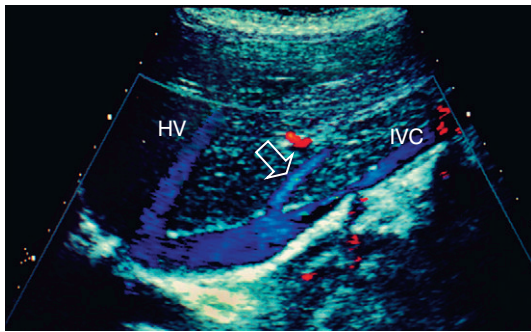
Longitudinal colour Doppler image of the liver and inferior vena cava (IVC) through the right flank. There is a prominent accessory hepatic vein (open arrow) from the inferior posterior segment of the right lobe of the liver (Couinaud segment 6). This vein joins the inferior vena cava approximately 3 cm inferior to the junction of the right middle and left hepatic veins (HV).
